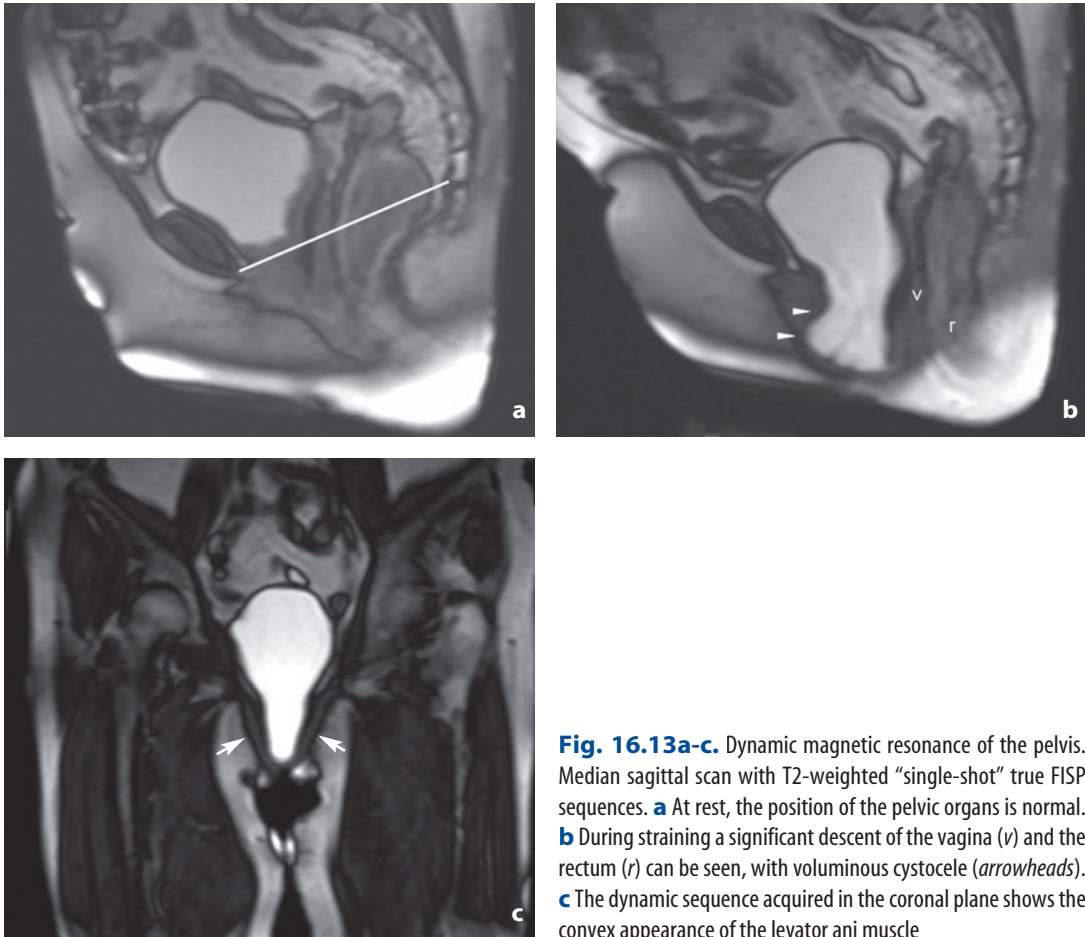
Dynamic magnetic resonance of the pelvis. Median sagittal scan with T2-weighted “single-shot” true FISP sequences. a At rest, the position of the pelvic organs is normal. b During straining a significant descent of the vagina (*v*) and the rectum (*r*) can be seen, with voluminous cystoceles (*arrowheads*). c The dynamic sequence acquired in the coronal plane shows the convex appearance of the levator ani muscle
